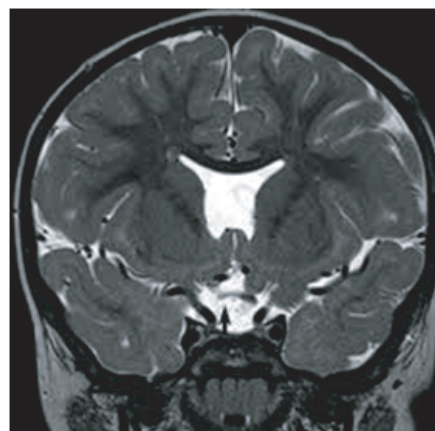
MRI of brain showing absence of septum pellucidum
